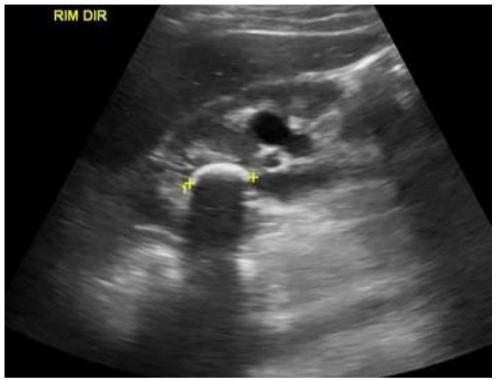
Ultrasound grey scale image of showing an upper pole calculus (measuring ~ 2.2 cm) in the right kidney casting a sharp posterior acoustic shadowing.
